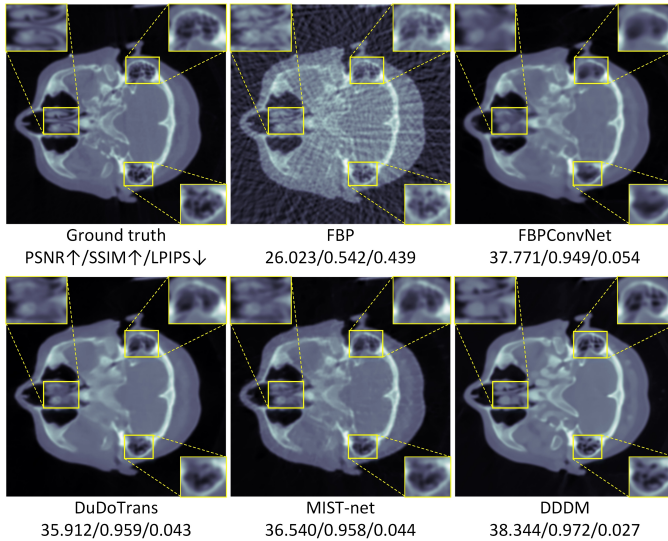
Reconstructed CT images for a head test sample.
